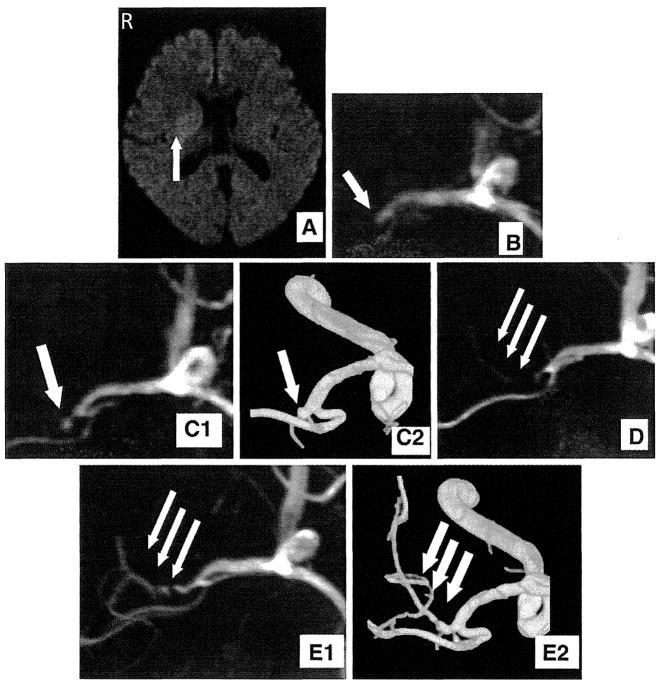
Magnetic resonance imaging (MRI) and 3D-digital subtraction angiography (3D-DSA). (A) Diffusion-weighted MRI showing the area of hyperintensity in the right basal ganglia and corona radiata (arrow). (B) Magnetic resonance angiography (MRA) performed on admission showing an obstruction of the insular segment of the right MCA (arrow). (C) A bulge-like change in the obstructing stump (arrow) observed on day 7 of MRA (C-1) as well as 3D-DSA (C-2). (D) A partial recanalization (arrows) from the obstructing stump detected on day 23. (E) Complete recanalization with the pearl-and string sign (arrows) were seen 6 months later on MRA (E-1) and 3D-DSA (E-2).
